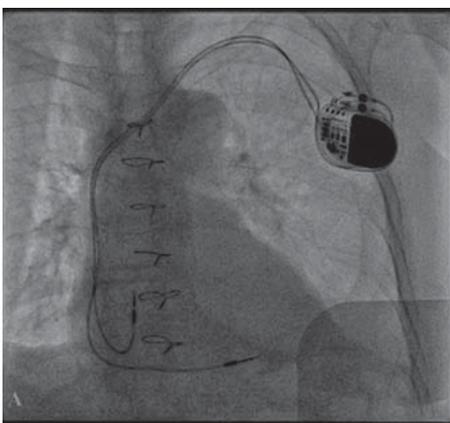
Image 'A' at the end of the procedure showing the implantation side of the pacemaker body and leads. Image 'B' is the chest X-ray one-day post implantation showing the pacemaker lead in place
